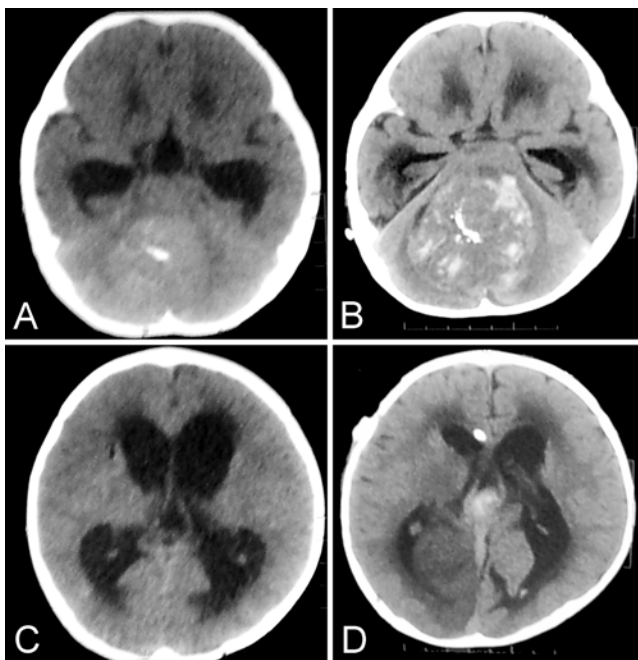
Case 2. Axial CT scans of the same patient in Fig. 1 before and after VP shunt placement. A and C: Scans before shunt placement showing marked hydrocephalus; note the ependymoma calcification. B and D: Scans after shunt placement showing posterior fossa ITH extending to the third ventricle. Note the tip of shunt and the decrease of ventricular size, as well as the secondary UTH and right occipital infarction due to posterior cerebral artery occlusion.
